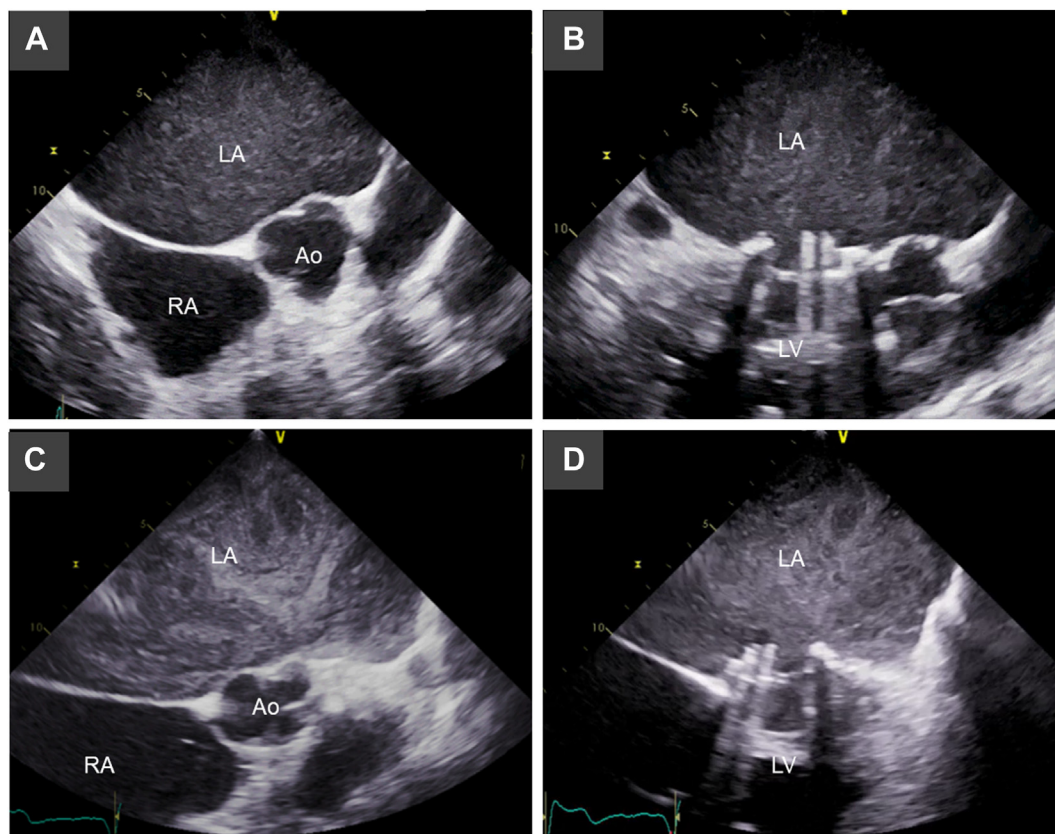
Transesophageal echocardiography (A, B) 7 years earlier and (C, D) on admission. Ao, aorta; LA, left atrium; LV, left ventricle; RA, right atrium.
